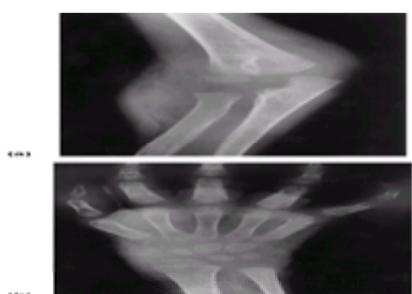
Juvenile chronic arthritis in a 4-year-old boy at the early stage. Radiographs of the elbow (a) and wrist (b) show marked soft tissue swelling and joint effusion.
